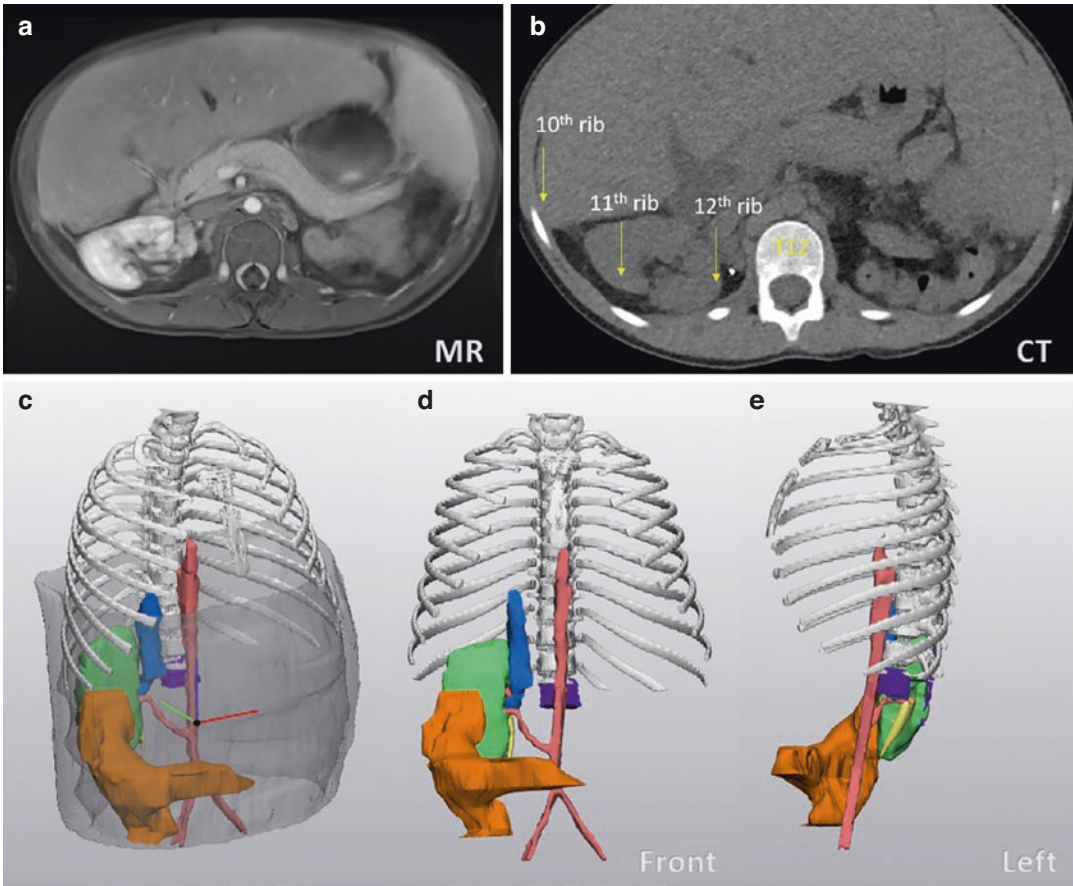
An 11-year-old girl with renal cell carcinoma in a right upper quadrant transplant kidney. (a) Axial STAR VIBE post-contrast image obtained during a magnetic resonance imaging (MRI) examination of the abdomen for preoperative planning. (b) Axial non-contrast chest computed tomography (CT) image where the osseous anatomy is identified in preparation for 3D modeling. A vertebral body from the upper abdomen was used to modify and combine anatomic structures between MRI
